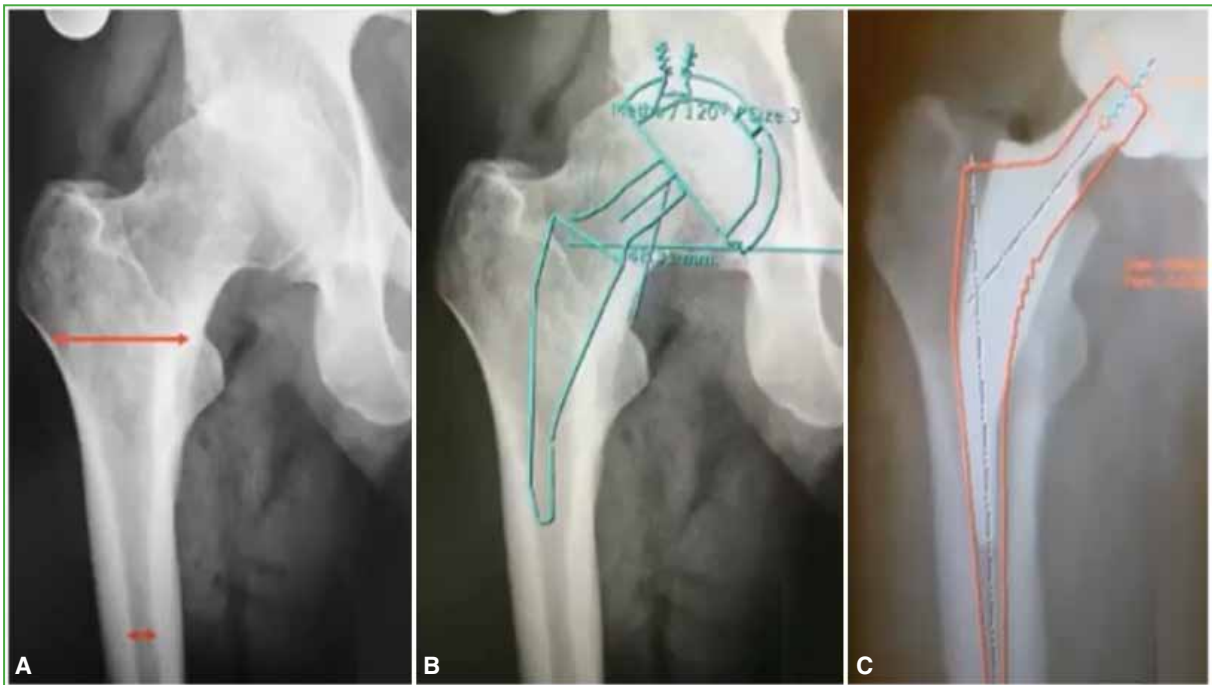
Anteroposterior radiograph of the right hip. The discrepancy between the proximal metaphysis and the diaphysis is observed, in a Dorr A femur (A). B. Preoperative digital planning with a short stem. The correct filling of the proximal metaphysis is visualized. C. Digital preoperative planning with a conventional uncemented stem. Engagement of the distal segment of the stem in the femoral diaphysis is observed.
